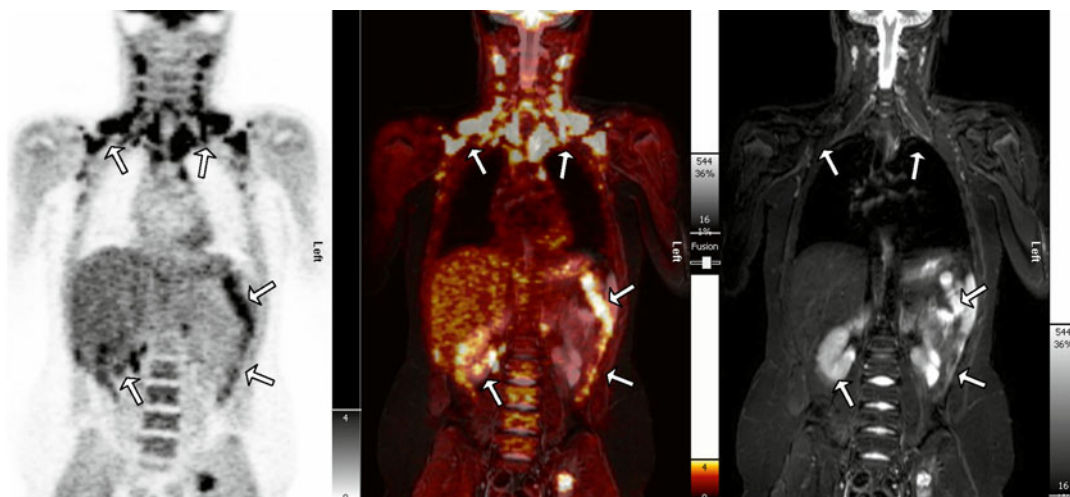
Simultaneous MRI/PET acquisition in an 11-year-old boy with an LCH lesion in the left iliac bone. In contrast to PET/CT, real simultaneous data acquisition
